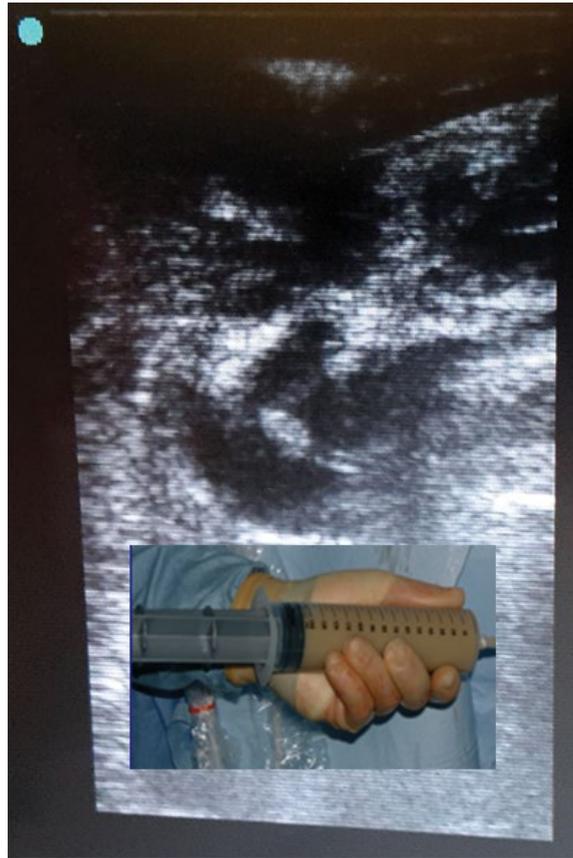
Ultrasound showing fluid supra-aponeurotic collection. Purulent material obtained by puncture.
